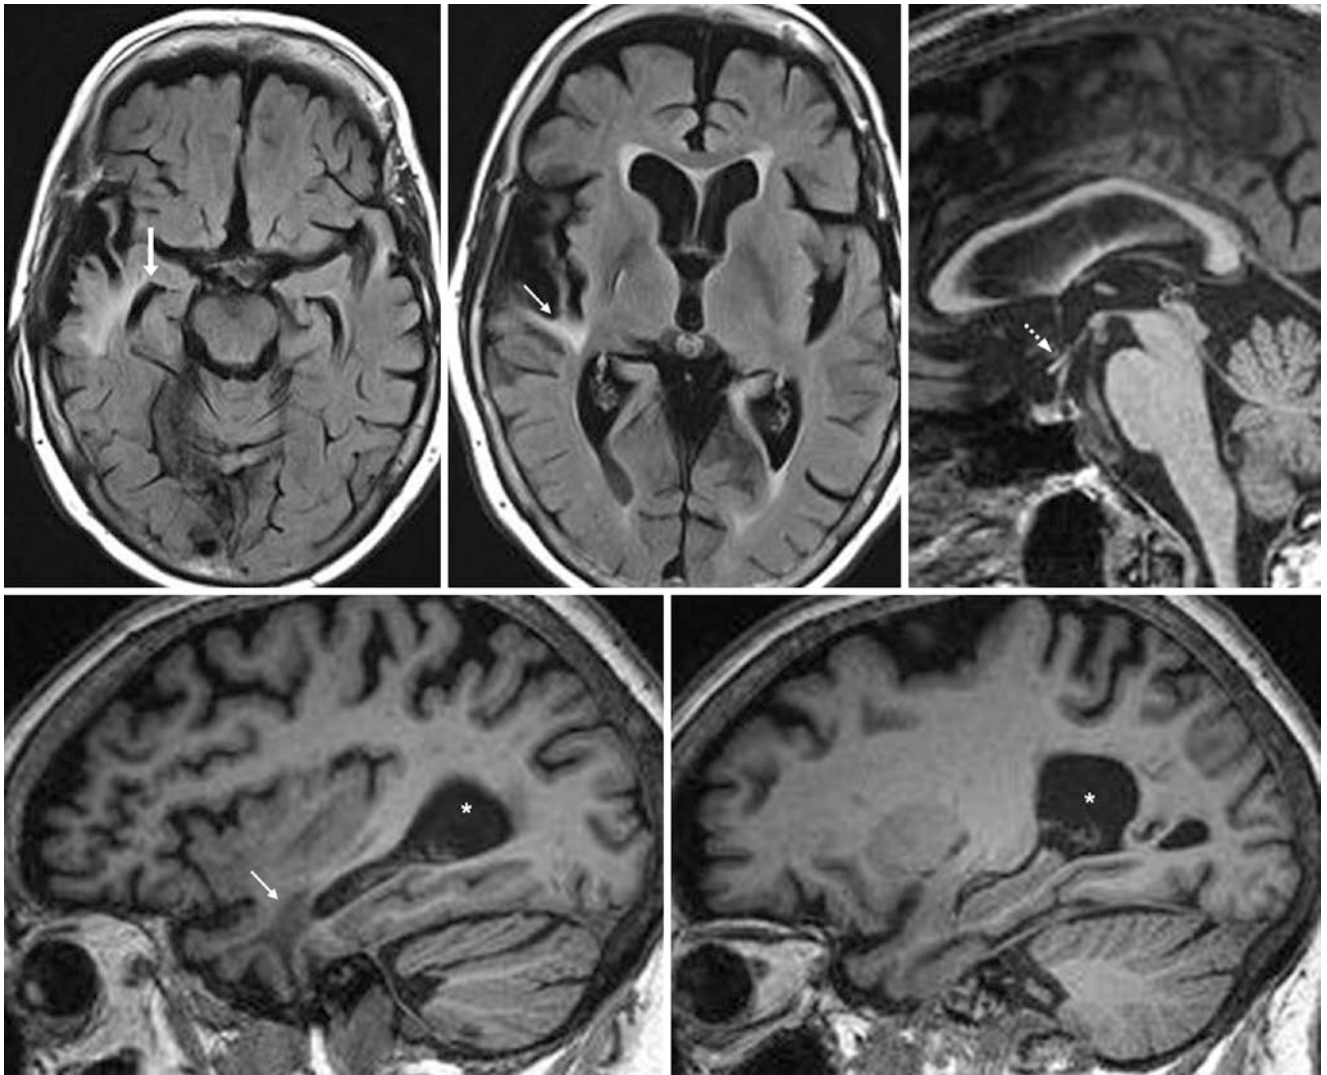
Comparison case of enlargement from focal atrophy. A 75 year old had right temporal horn enlargement (*arrows*) caused by focal right temporal atrophy (*thin arrows*) on axial FLAIR (*top left and middle*). Note a normal optic recess (*dotted arrow*) on midline sagittal
